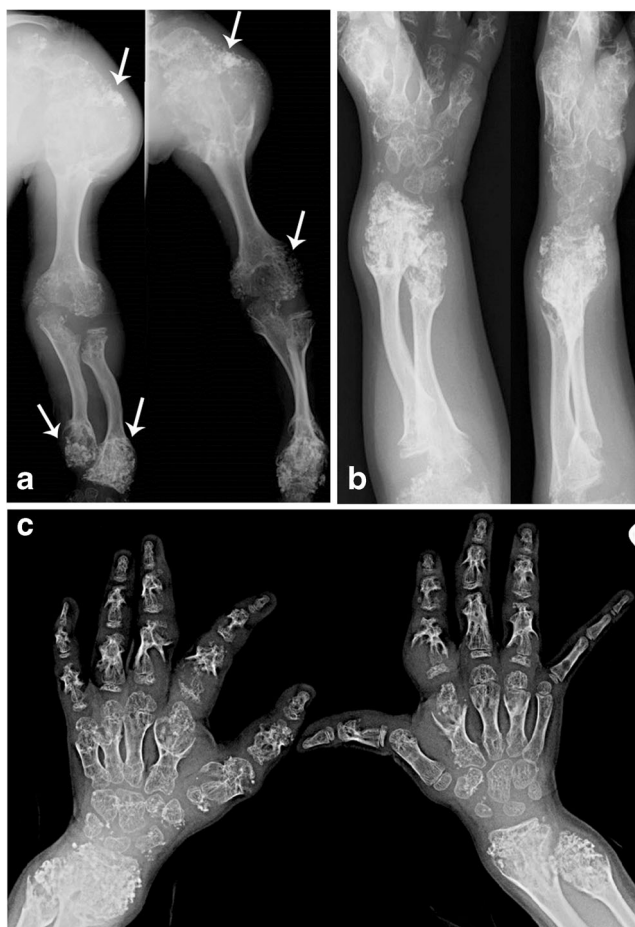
Radiographs of the upper extremities. The radiographs of a left arm, b right wrist, and c both hands exhibited bulbous expansive metaphyses of long bones as well as irregular lucencies of metaphyses interspersed with stippled calcification. Some fingers revealed bulbous enlargement and streaks of lucencies through the metaphyses. Again noted, the speckled calcification (*arrows*) is cartilage calcification in a typical “rings and arcs” pattern. *Vertical streaks of lucencies* represent columns of cartilages
